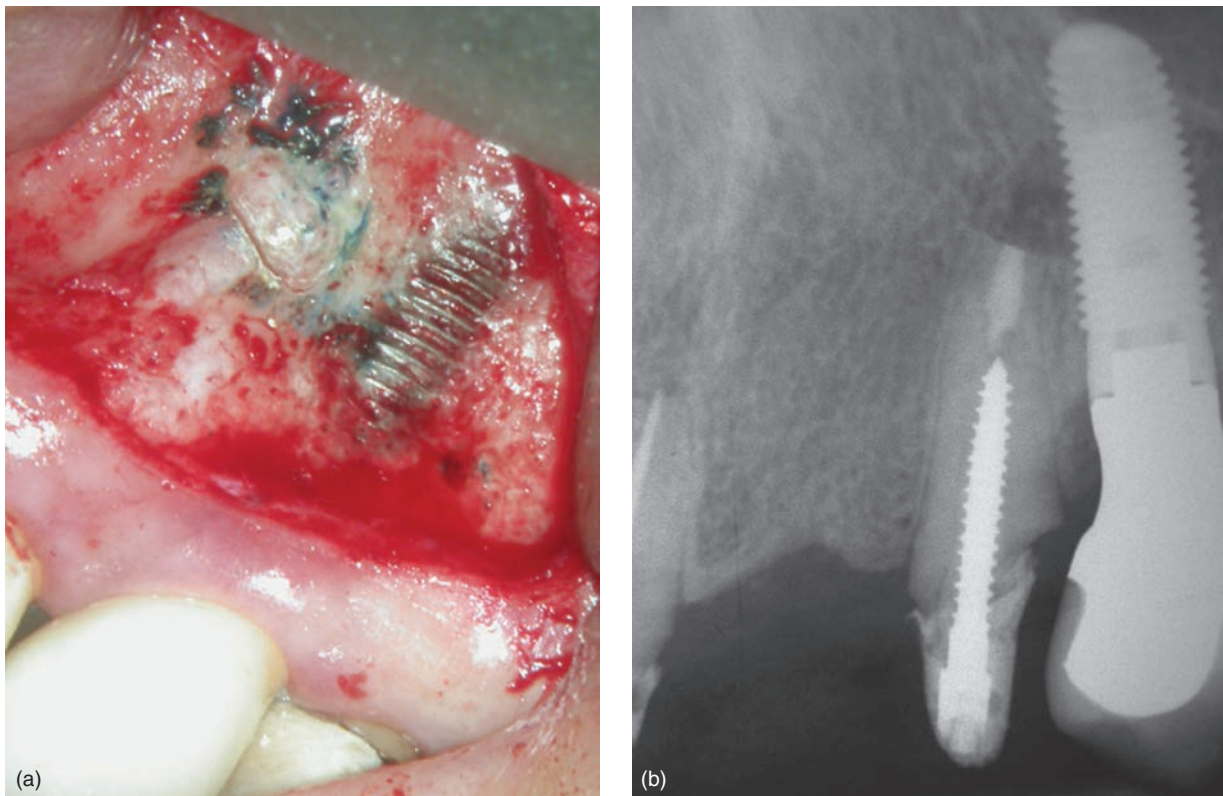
Second left maxillary premolar, with insufficient previous root canal treatment and post. Surgery initiated due to patient's constant pain upon palpation in area of the root tip. (a) Intraoperative clinical situation revealed exposed implant threads that were the original cause of pain to palpation. (b) Postoperative radiograph after endodontic microsurgery.
